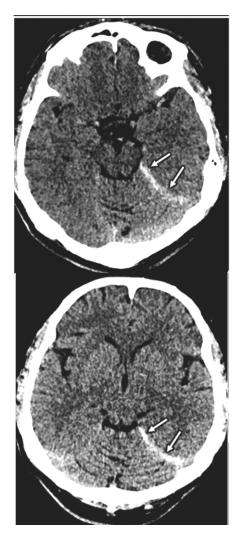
Isolated tentorial SDH in a 78 year old male patient, presenting after a fall injury at baseline (picture on left) and at 6 hour post initial CT scan (picture on right).
